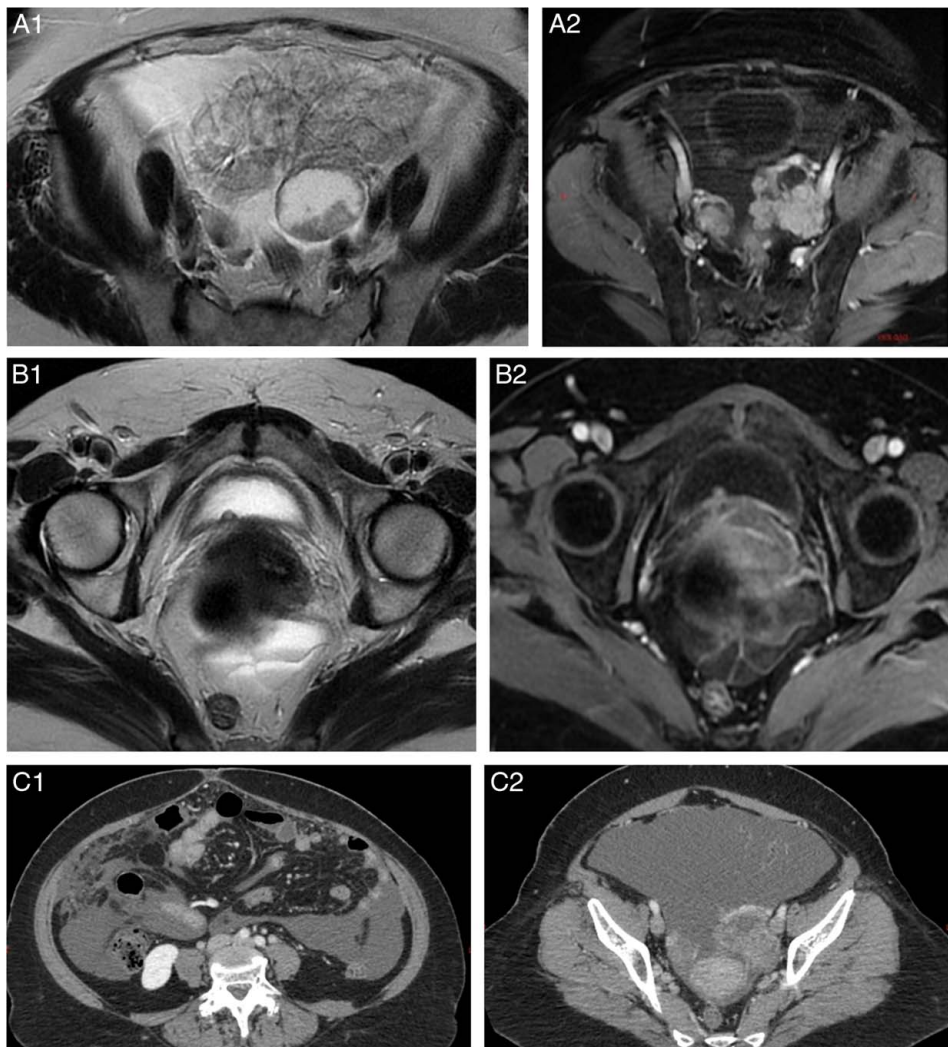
(A1) Axial T2 and (A2) Axial T1 post contrast images of the pelvis showing bilateral ovarian complex enhancing lesions in keeping with ovarian neoplasm with ascites. (B1) Axial T2 and (B2) Axial T1 post contrast images of the pelvis showing focal enhancing urinary bladder nodule and complex ascites with enhancing septations. (C1, C2) Contrast enhanced computed tomography images of the abdomen and pelvis showing ascites with omental thickening and peritoneal deposits.
